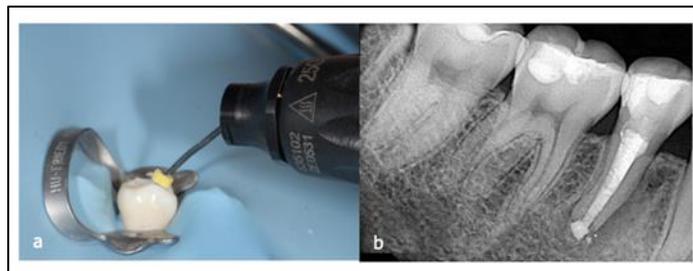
(a) Obturation with warm vertical compaction technique. (b) periapical radiograph confirmation
